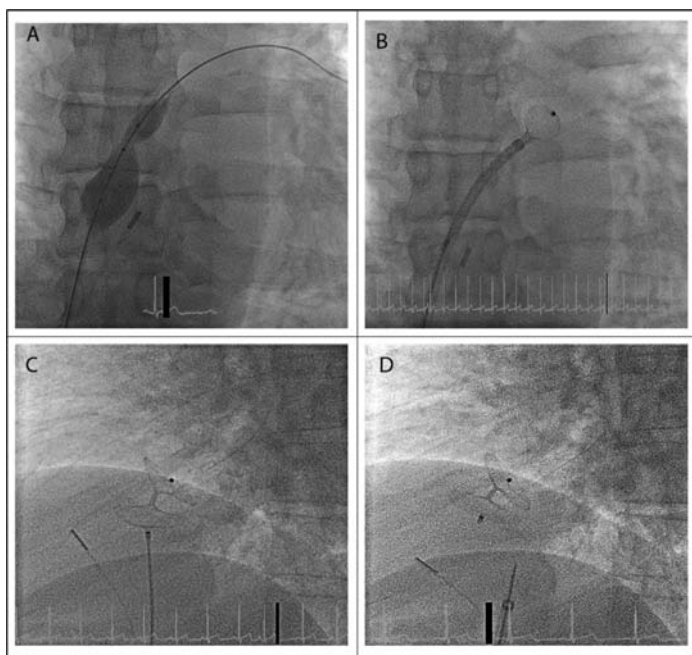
Patent foramen ovale closure using Amplatzer device. Panel A demonstrates balloon sizing of the PFO tunnel after crossing the PFO using a wire. The intracardiac echocardiography probe is visible next to the balloon. Panel B demonstrates deployment of the left atrial disk of the Amplatzer occluder device. Panel C demonstrates the deployment of the right atrial disk of the Amplatzer occluder device. Panel D demonstrates the device in place after its release from the delivery catheter.
